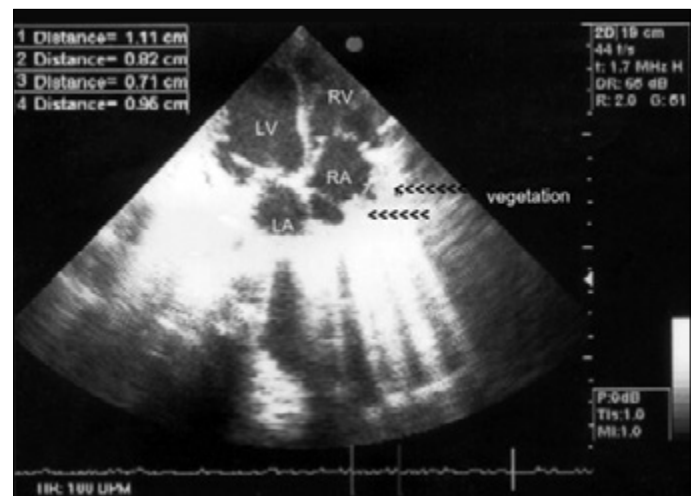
Echocardiography-vegetations on the right atrium wall
